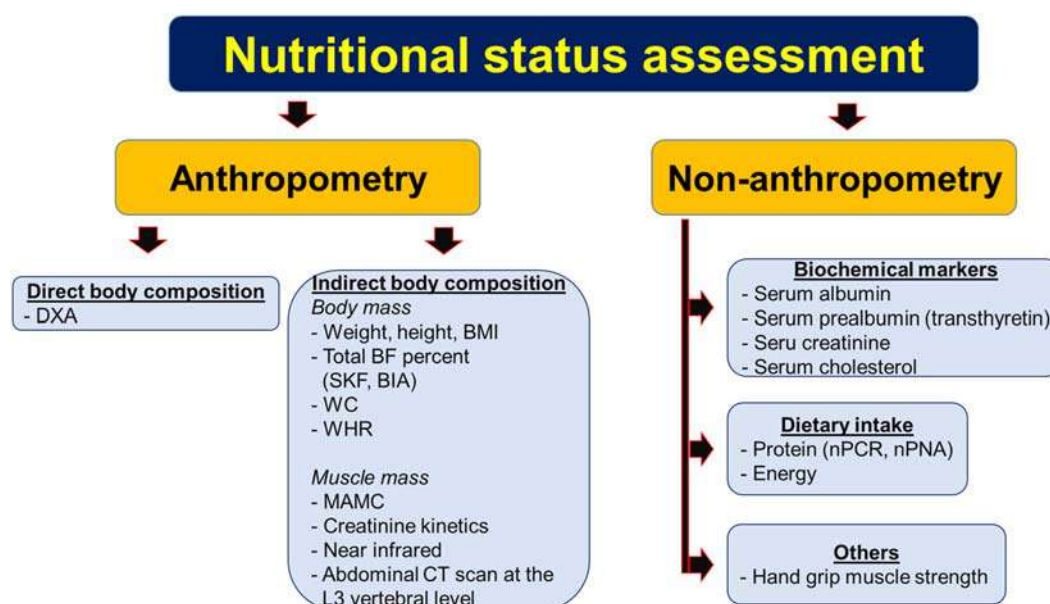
Overview methods for nutritional assessments. *BF*, Body fat; *BIA*, bioelectrical impedance analysis; *BMI*, body mass index; *DXA*, dual-energy X-ray absorptiometry; *L*, lumbar; *MAMC*, midarm muscle circumference; *nPCR*, normalized protein catabolic rate; *nPNA*, normalized protein nitrogen appearance; *SKF*, skinfold thickness; *WHR*, waist-to-hip ratio; *WC*, waist circumference.
